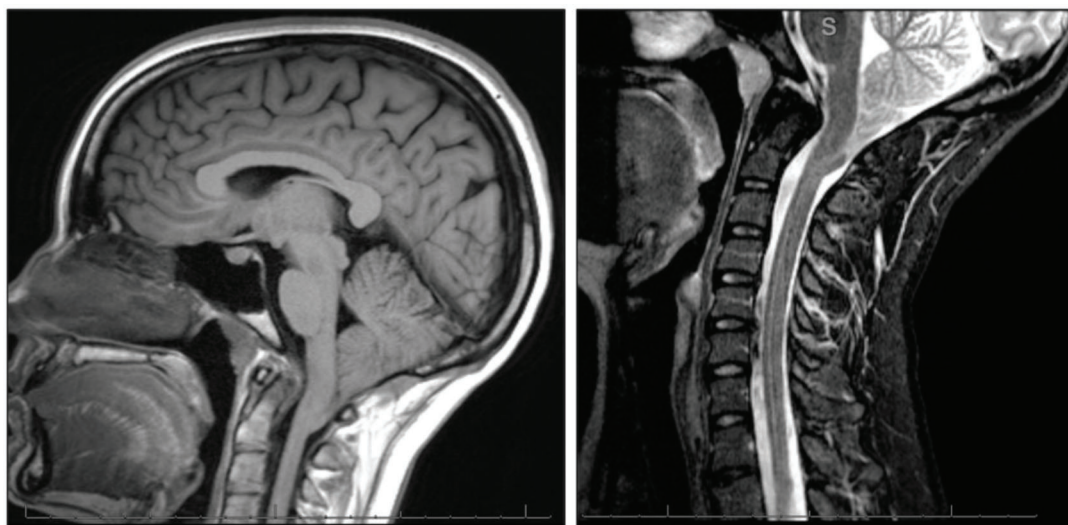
Magnetic resonance imaging of brain (left) and cervical spine (right) demonstrating Chiari type I malformation.
